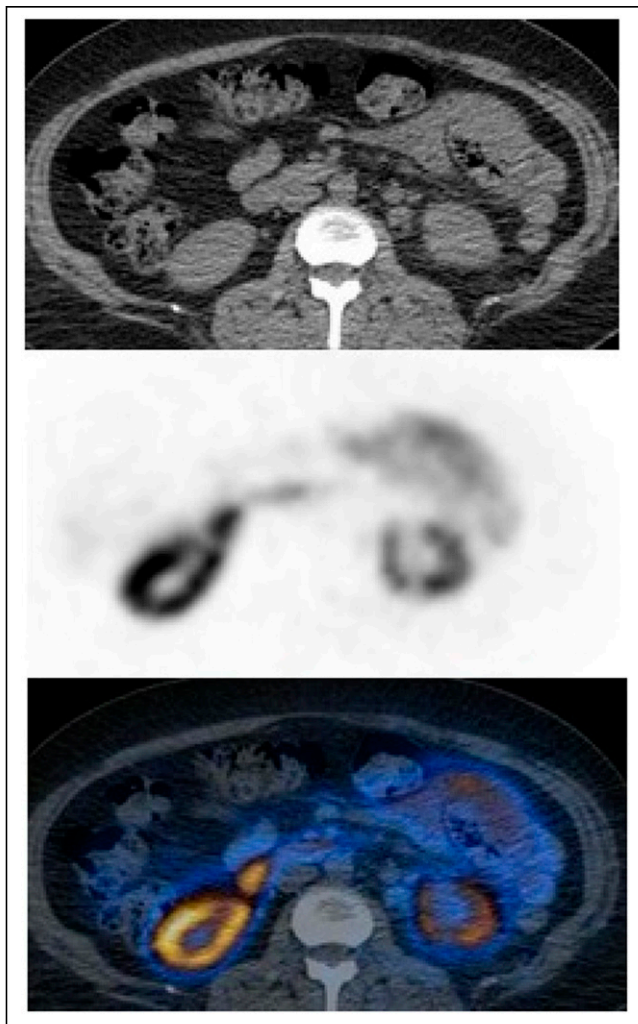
^{68}Ga -PSMA-11 PET/CT (selected transaxial CT [top], PET [middle], and AC PET/CT [bottom]) images demonstrating reduced uptake in lower pole of left kidney and small cortical defect.
